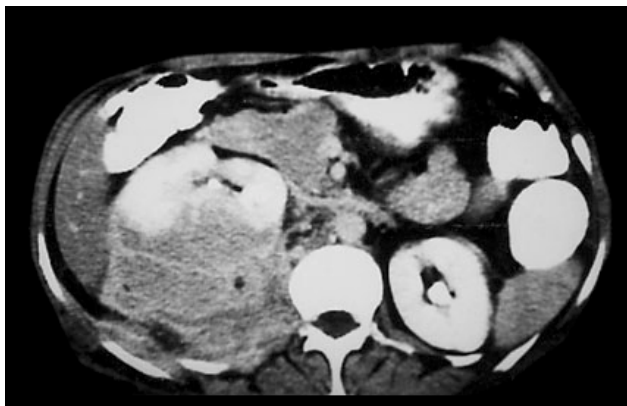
Abdominal CT scan showing heterogeneous retroperitoneal mass involving the right kidney.
